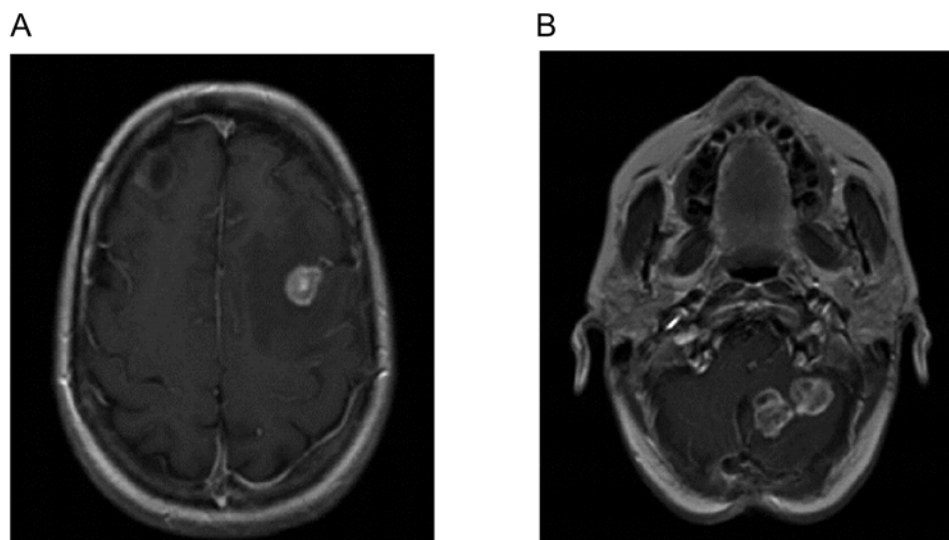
Axial MRI images of multiple brain metastases in a HER2-positive breast cancer patient. Lesions in the left frontal lobe (A) and left cerebellum (B) show uptake of gadolinium contrast agent in T1-weighted scans. Images from (17).
